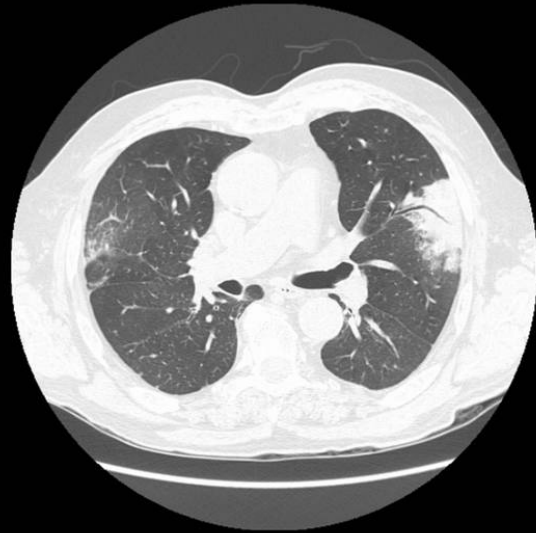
Axial HRCT showing peripheral areas of consolidation in the upper lobes in a patient with history of bronchial asthma and blood eosinophilia.
